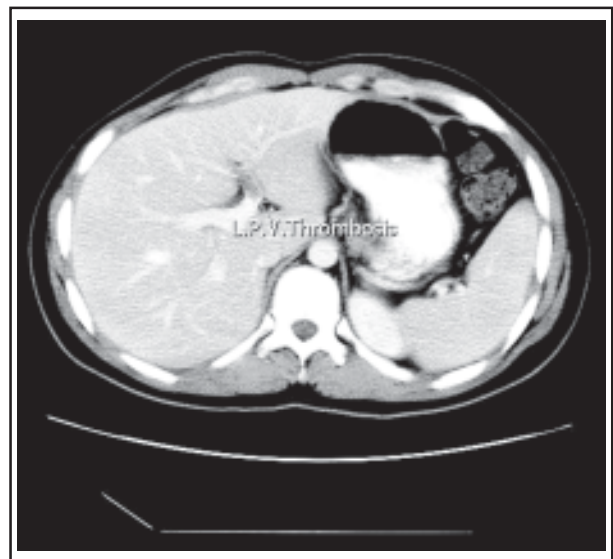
Contrast CT scan of the abdomen shows (arrow) filling defect of left branch of portal vein suggestive of Thrombosis.
